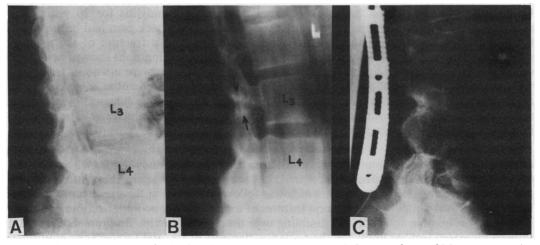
Case 3. A: plain radiograph of lumbar spine. B: tomogram reveals fracture of pars of L3. C: postoperative view of fixation
